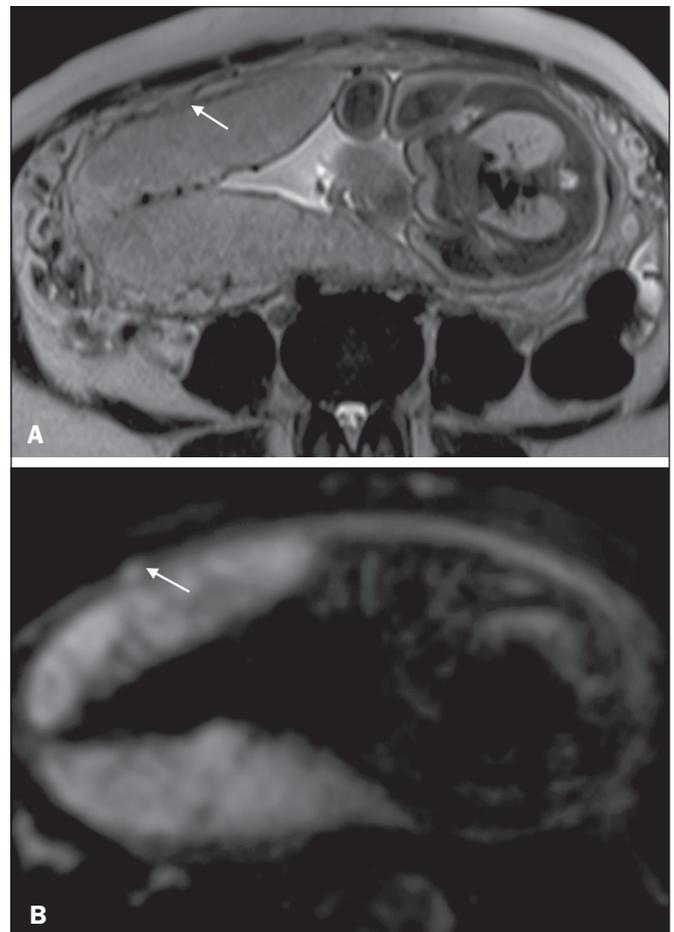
A 39-year-old patient. Axial T2-weighted HASTE and DWI sequences (A and B, respectively), showing a focal rupture of the myometrium (arrow).
